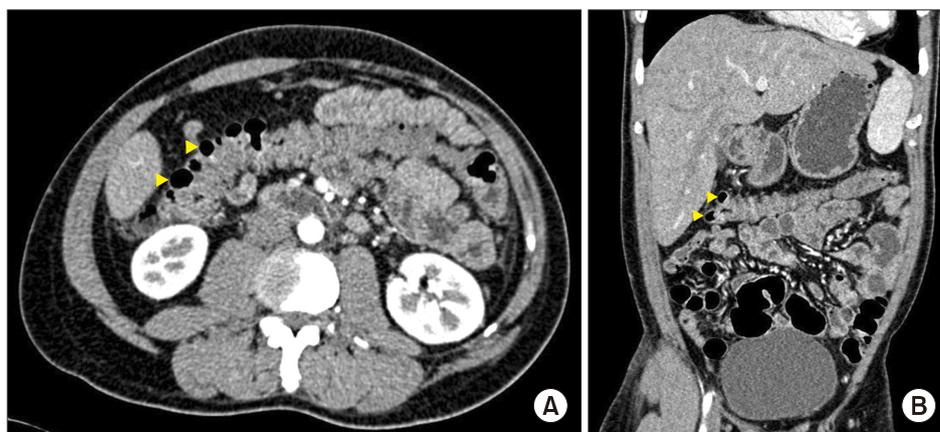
Computed tomography of the abdomen (A) axial view, (B) coronal view showing multiple outpouchings of colon (indicated by yellow arrows) at the hepatic flexure.
